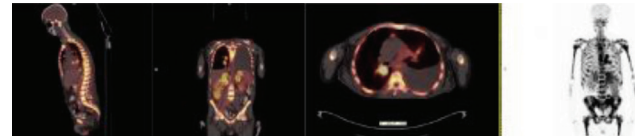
Left to right Sagittal Coronal Axial and MIP image of whole body FDG PET/CT. There are multiple foci of intense FDG uptake consistent with Burkitt's Lymphoma in the cranium, thorax, mediastinum, abdomen, retroperitoneum and pelvic region
